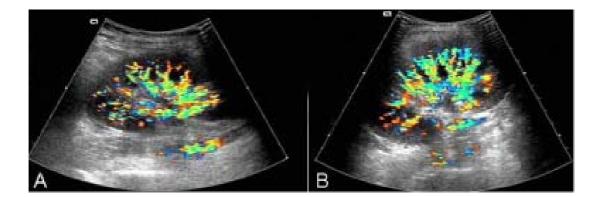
The two-dimensional color Doppler imaging did not change when change of 3D-CDUI was already obvious. A: before treatment; B: 10 day after treatment.
